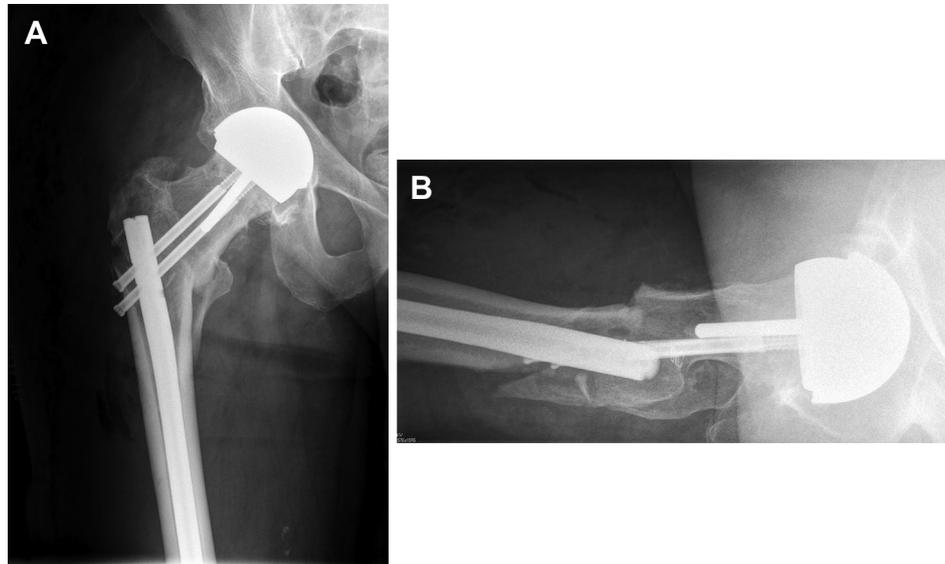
Postoperative X-rays of the reduction and fixation of the fracture with the reconstruction nail. (A) Anteroposterior and (B) lateral views.
